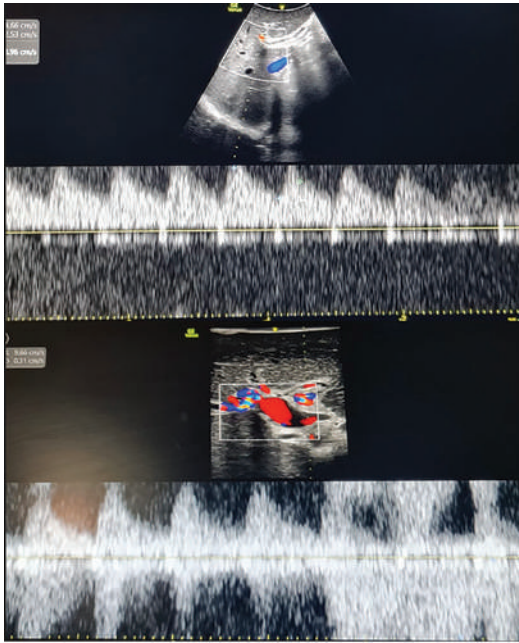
Intraoperative Doppler USG.
